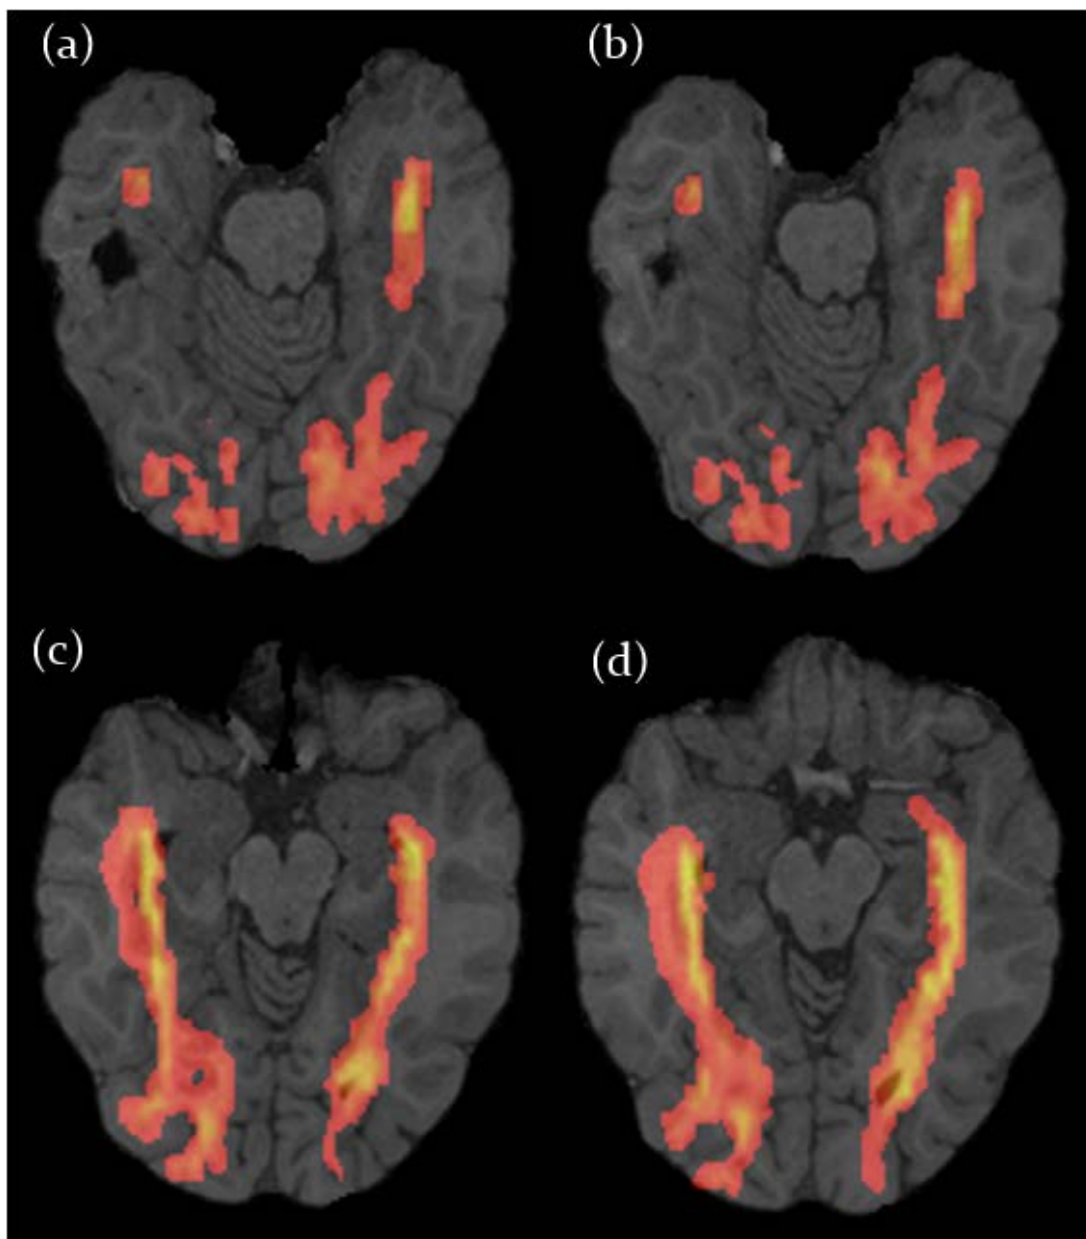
Tuberculos sclerosis lesions in the second brain tumour patient. The lesions in black can be seen near to the optic radiations, which are coloured red and yellow. The tractography results were co-integrated with the MRI T1-weighted scan in this image. See the main text for details of each image.
